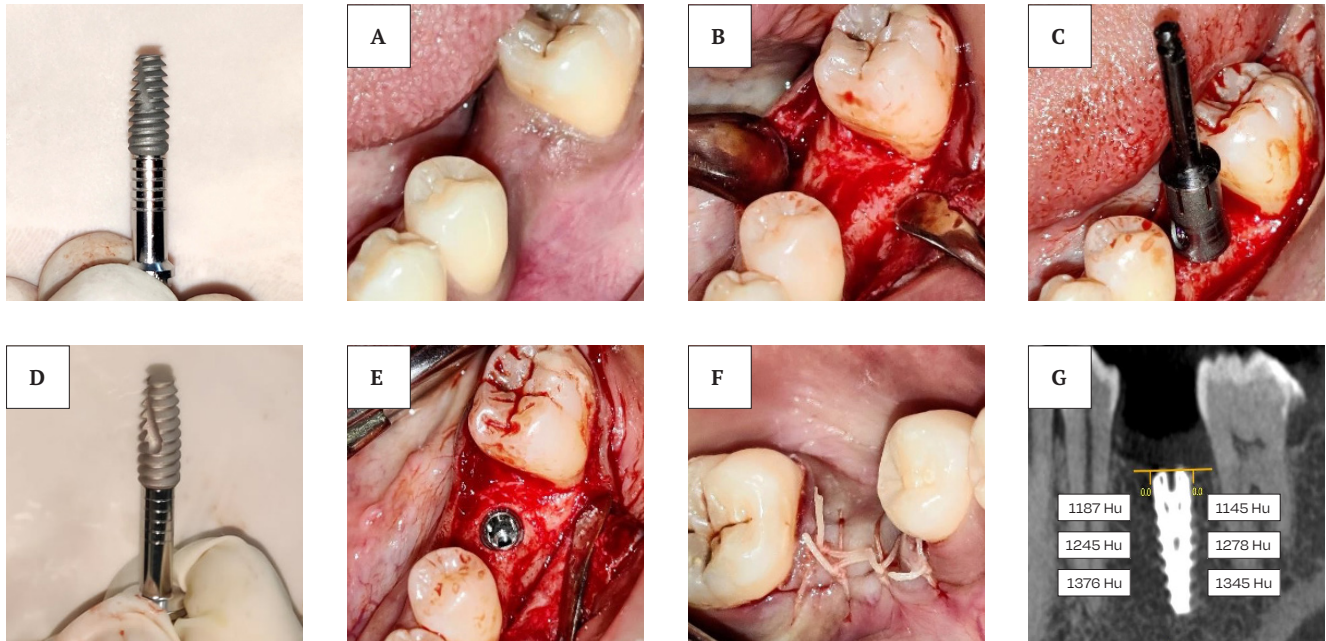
V-Shaped Implant Design. Fig. 5A-5G Steps in V-Shaped Thread Design. (A) Pre-operative View, (B) Flap Reflected (C) Parallelism checked with osteotomy drill (D) V-Shaped Implant (E) Implant Placed (F) Sutures Given (G) Baseline CBCT showing Crestal bone loss and Bone Density.
